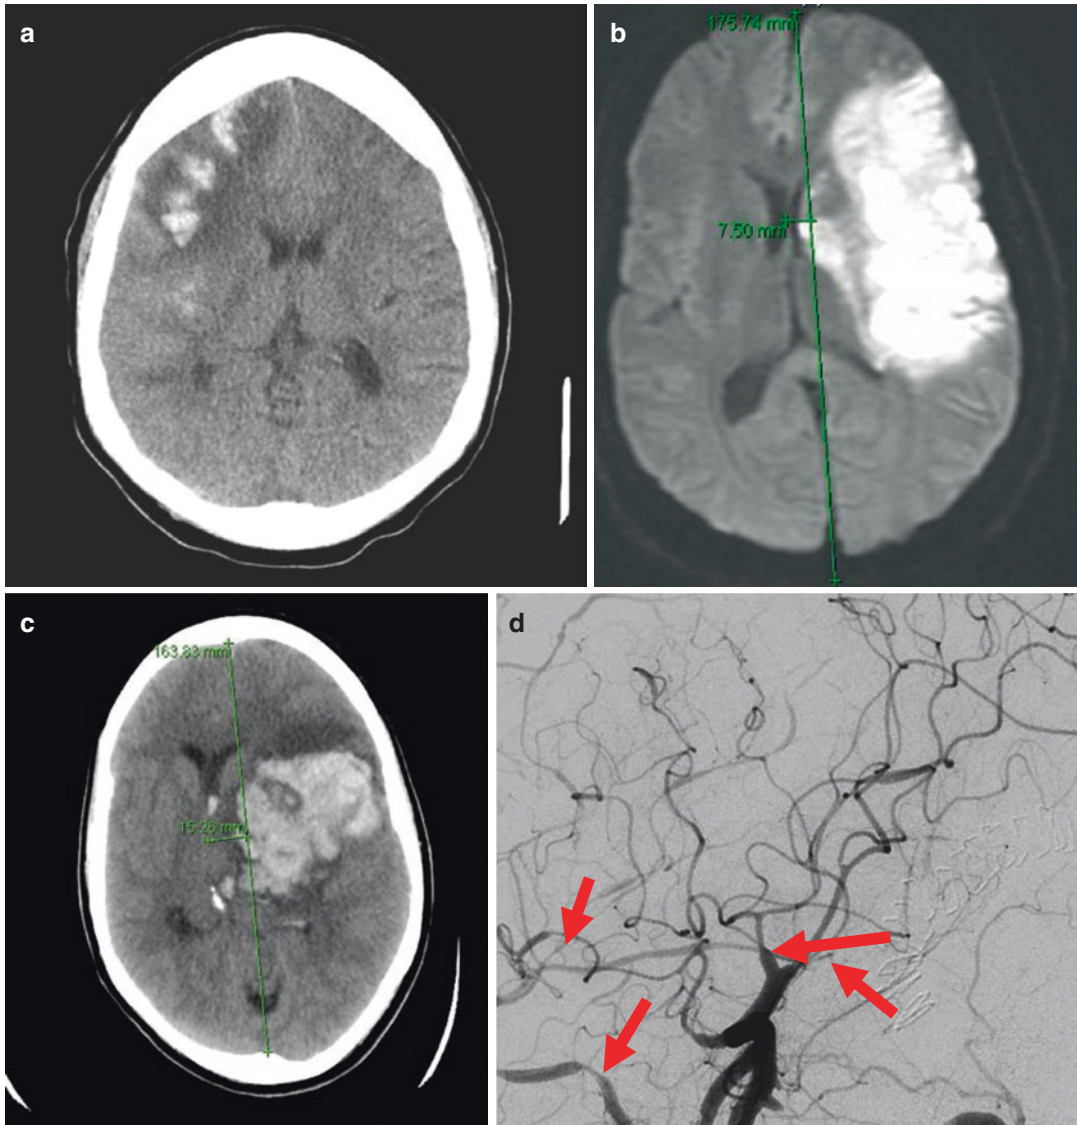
Pregnancy-related stroke. (a) Diffusion-weighted magnetic resonance image of left middle cerebral artery acute embolic infarct in a 33-year-old woman, 4 weeks postpartum. Note midline shift due to swelling. (b) Computed tomography without contrast enhancement, showing right frontal infarction with hemorrhagic conversion in a young woman with sickle cell disease and preeclampsia, postpartum day 1. (c) Computed tomography
